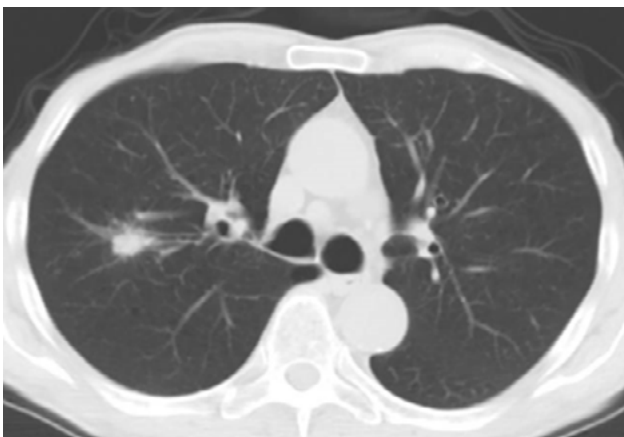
CT scan -Right upper lobe nodule (18 x 12 mm) with bronchus sign
